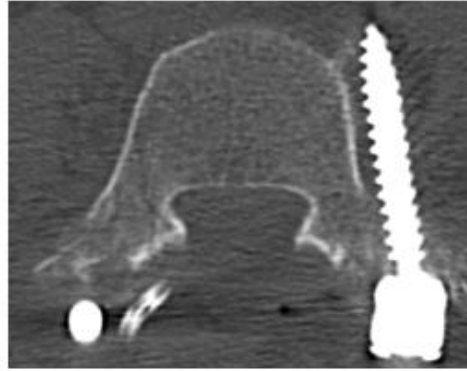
Axial computed tomography image depicting lateral breach of a pedicle screw intended for the L4 vertebrae.
